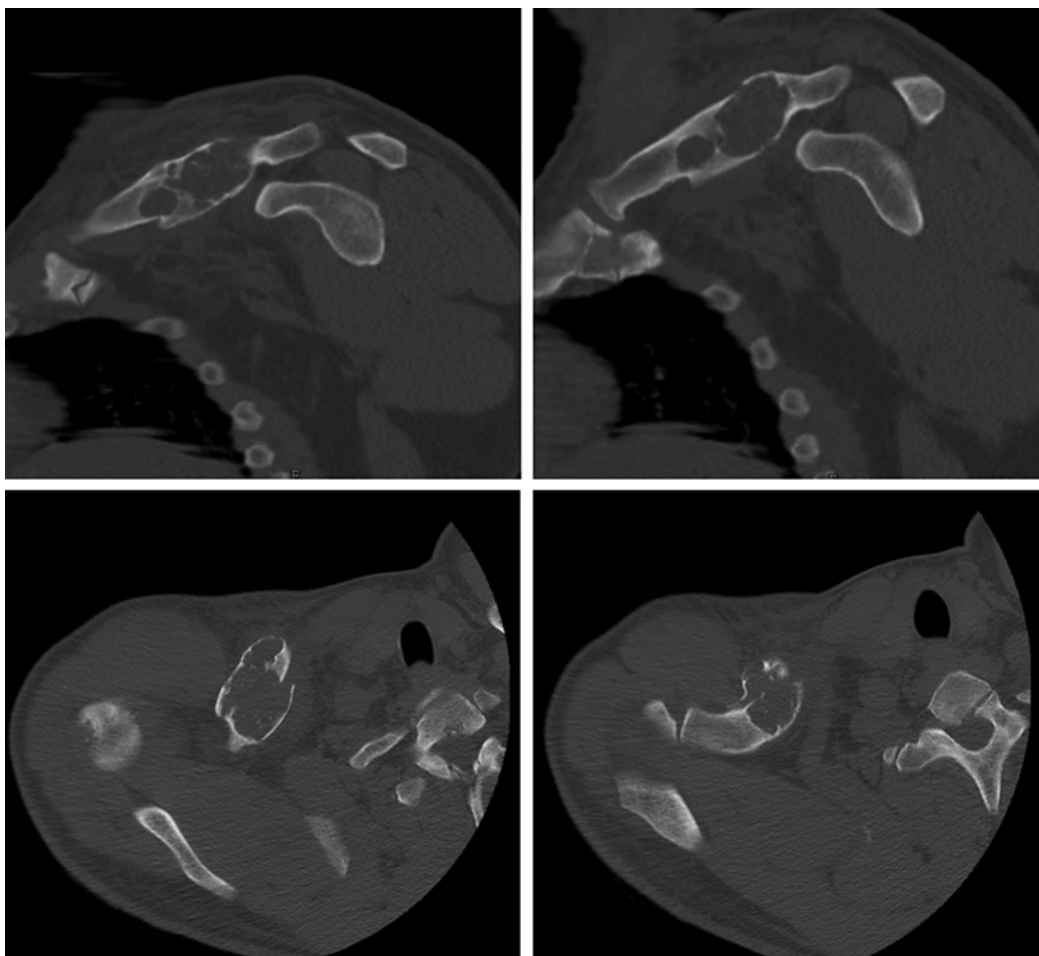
Computed tomography revealing an osteolytic expansive lesion of 6 × 3.5 cm dimension with chondroid matrix core and internal septa, with an antero-superior incomplete pathologic fracture.
